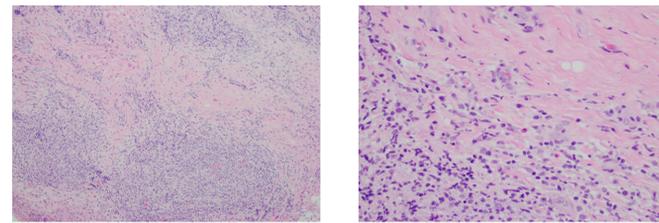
Transesophageal biopsy of mediastinal mass (2019) with extensive fibrosis and chronic lymphocytic infiltrate
